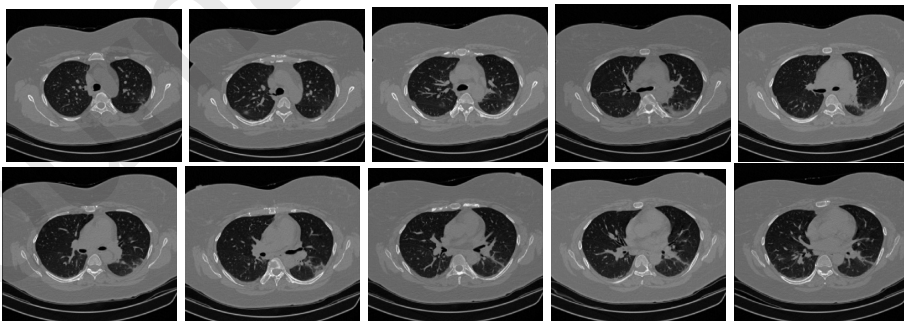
Slices from COVID-19 cluster center 2 in COV19-CT-DB, which is consistent with COVID-19 pneumonia bilateral thickening filtrates.
